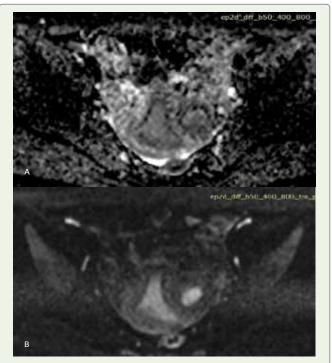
DWI-ADC images showing diffusion restriction with corresponding hypo intensity in the lesion.
